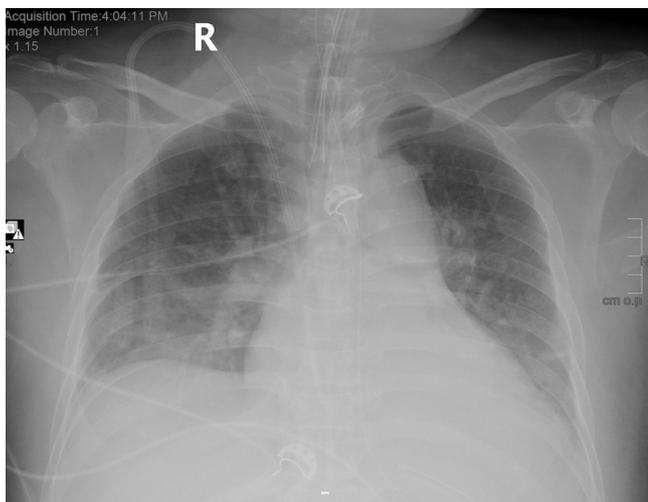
Chest X-ray after extracorporeal membrane oxygenation decannulation. There is almost complete clearing of infiltrates in the right parahilar area. No congestion and no new infiltrates.
